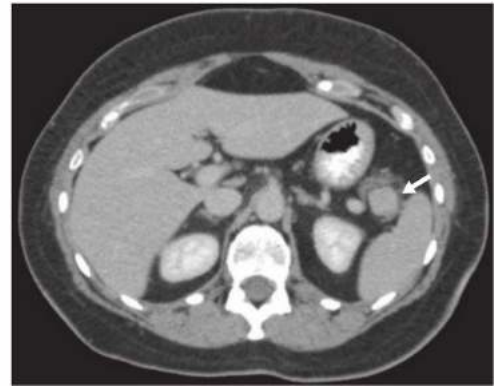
• Axial cut of a CT scan demonstrating a 2-cm insulinoma in the tail of the pancreas (marked by arrow). This scan, an MRI scan, and an endoscopic ultrasound all reported this lesion to be an accessory spleen as it was exophytic off the pancreas tail and had identical imaging characteristics as the spleen on all three imaging modalities.
